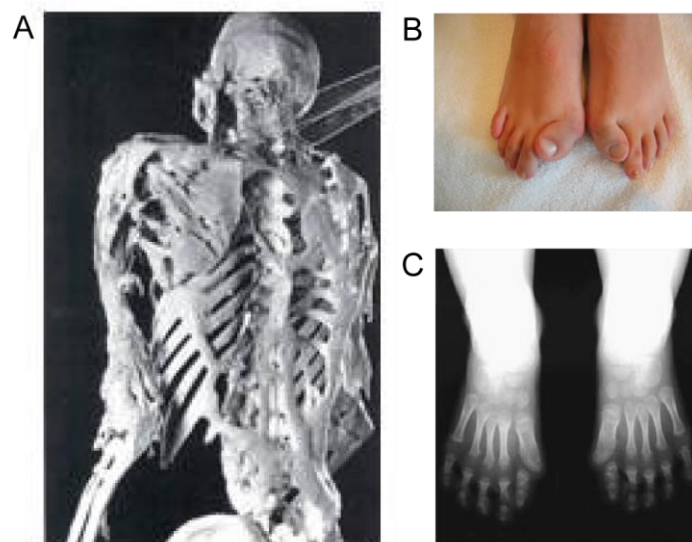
Classical symptoms of FOP patients. (A) Skeleton of Harry Eastlack, who lived with FOP to age 39, showing ectopic bone formation (on display at The Mutter Museum of The College of Physicians in Philadelphia). (B) photograph and (C) radiograph recording shortened great toes as an early diagnostic for FOP [8].
